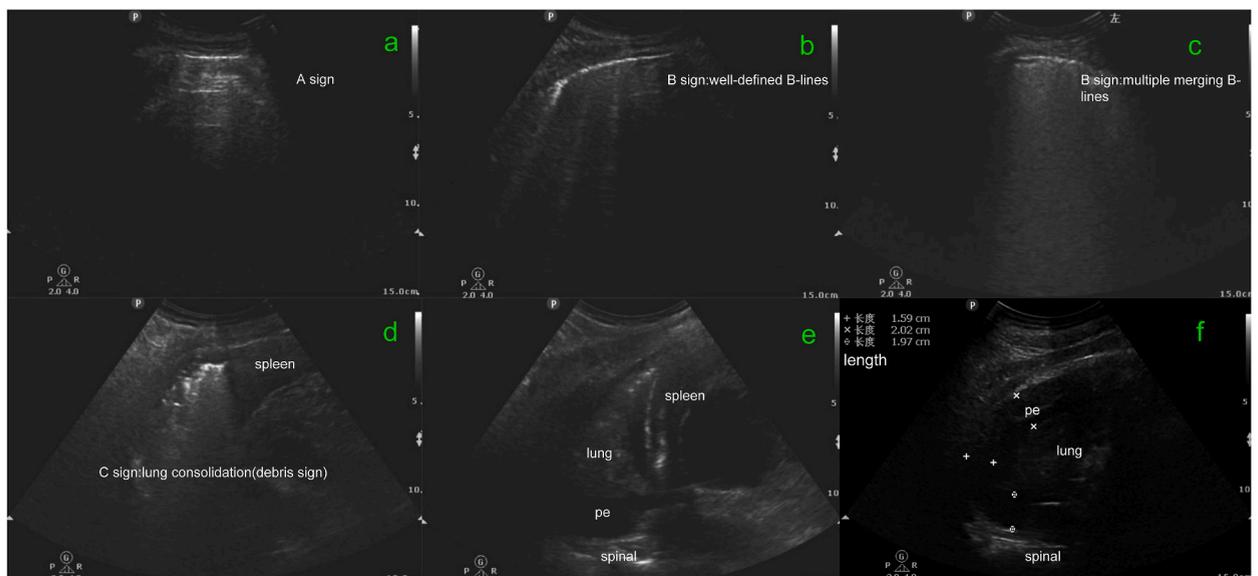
(a) Parallel A-lines or fewer than two isolated B-lines, (b) well-defined B-lines, (c) multiple merged B-lines; (d) C sign (lung consolidation): Debris sign (slight lung atrophy without large pleural effusion); (e) C sign (lung consolidation) - Compressive atelectasis formed by large amounts of pleural effusion (with compressed lung tissue in the centre), pe: pleural effusion; (f) Ultrasound probe scanning of the axillary line behind the transverse section above the base of the lung. After cardiac surgery, the patient had consolidation of the lower lobes of the lung, and the depth of pleural effusion was 1.97 cm paravertebrally, 1.59 cm dorsally, and 2.02 cm laterally, so the final maximum depth of pleural effusion was 2.02 cm.
